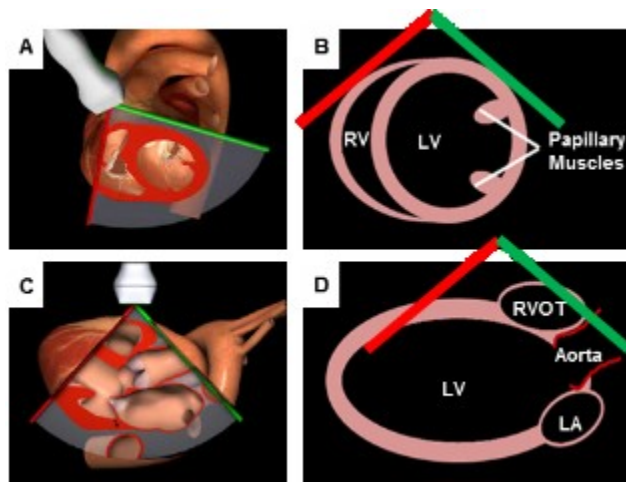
B-mode transthoracic echocardiography imaging.
